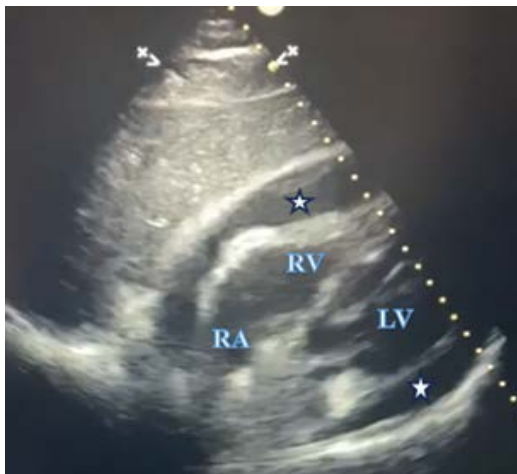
Subcostal transthoracic echocardiographic image showing a large pericardial effusion (*) surrounding the heart, causing compression of the right atrium, consistent with cardiac tamponade. (RA: Right atrium RV: Right ventricle LV: Left ventricle)
